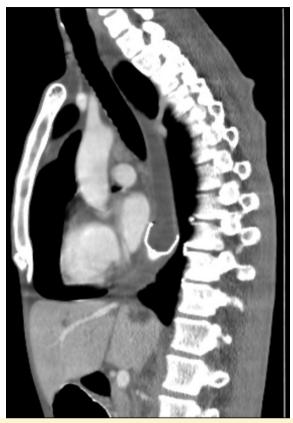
Lateral CT-sectional image of the esophagus stent considered to be fistulized. CT, computed tomography.
